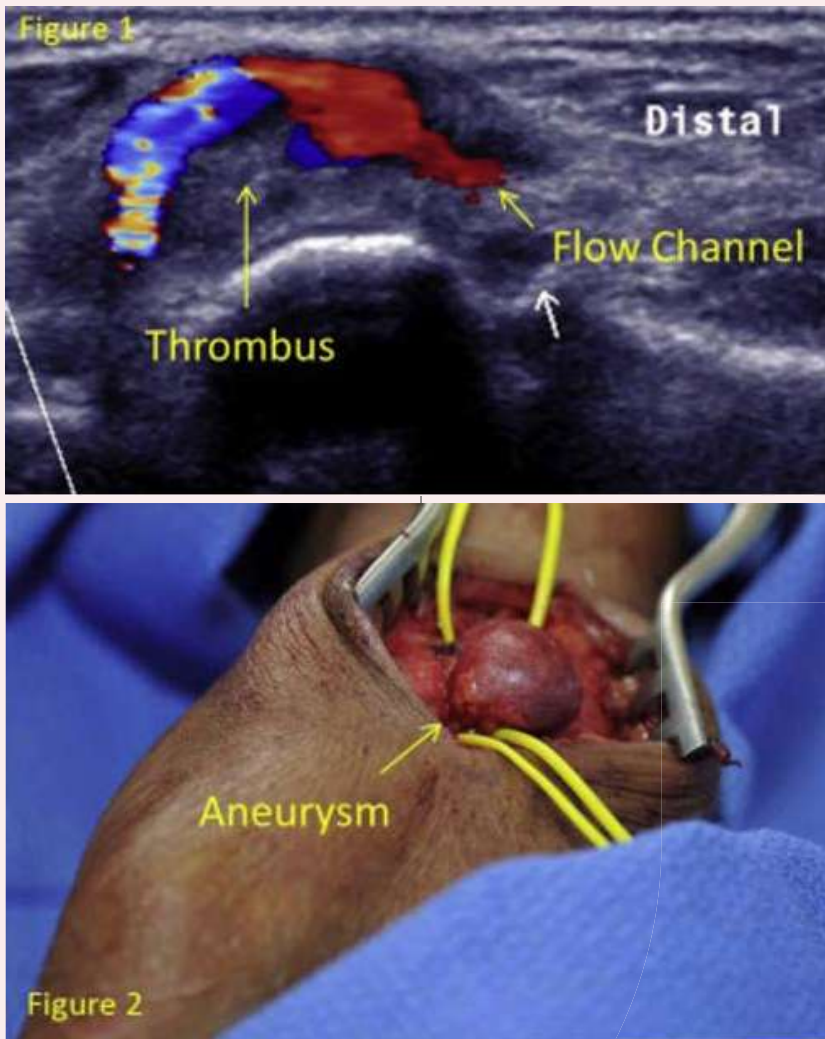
and Figure 2: Figure 1 showing ultrasound image of the radial artery aneurysm. Figure 2 shows the operative exposure of the radial artery aneurysm.
